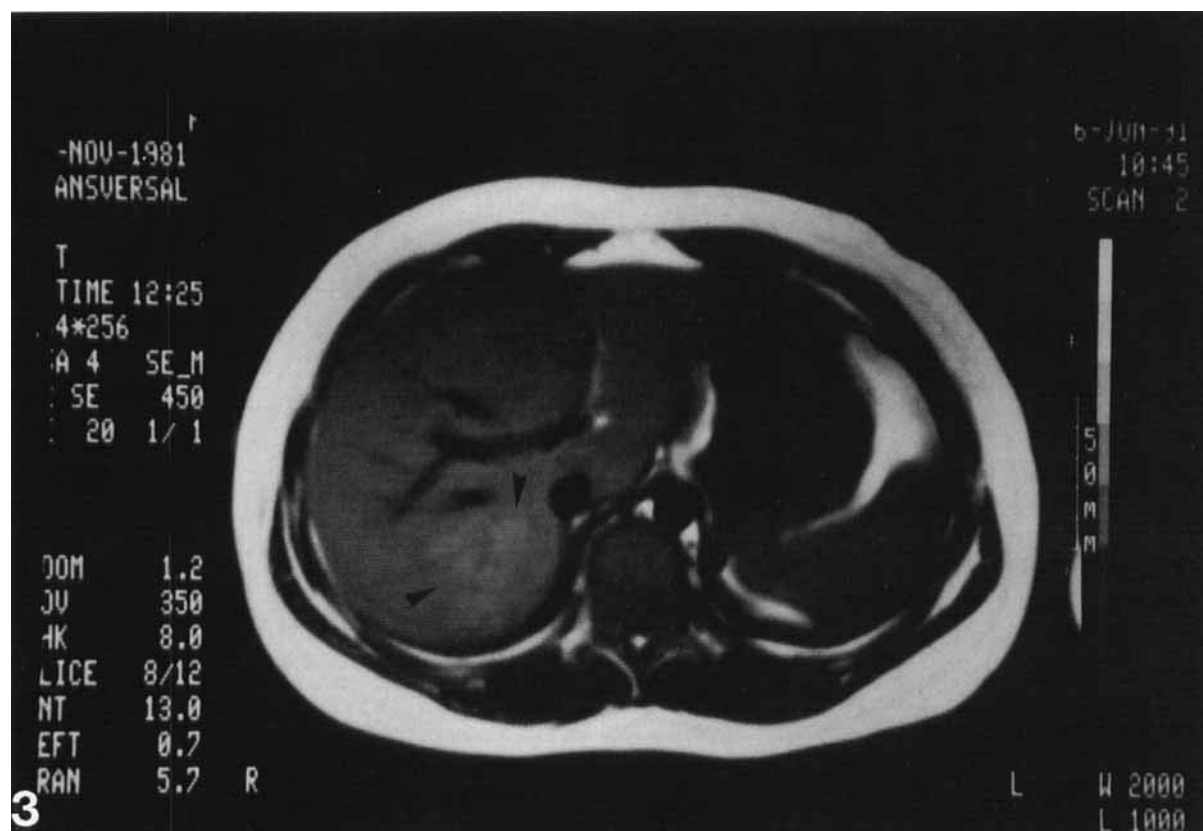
CT scan. The hepatic CT scan shows multiple hyperintense hepatic nodules.
